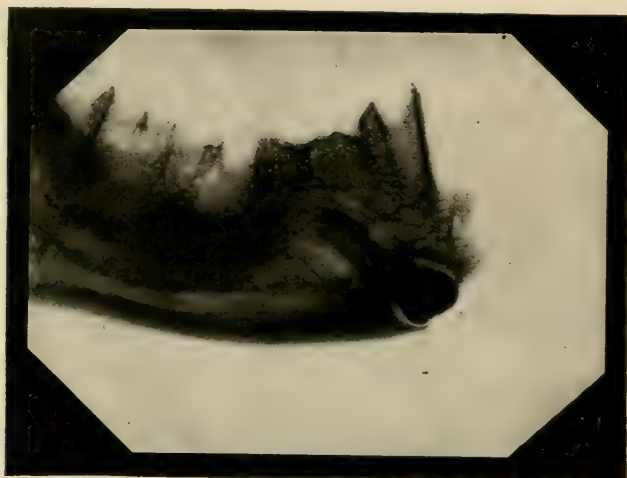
Radiograph of Figure 417.
